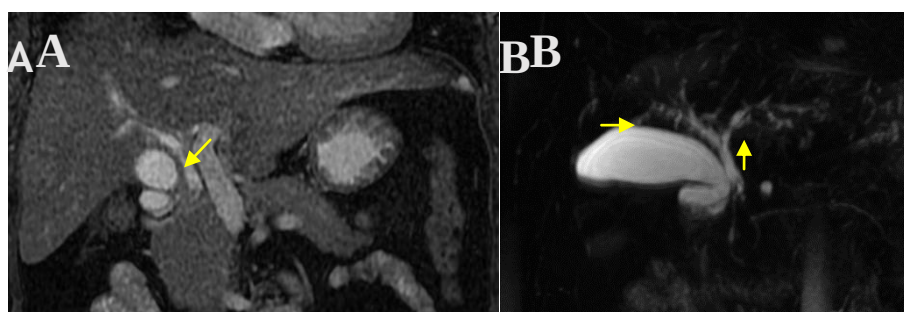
&2B: A fifty-year-old male, H/o jaundice; Coronal T2 W MRI and Reformatted 3D MRCP images shows diffuse irregularity of the intrahepatic biliary radicles in the form of narrowing (arrow), stenosis, strictures (right arrow) and ectasia up arrow) of the involved bile ducts.
